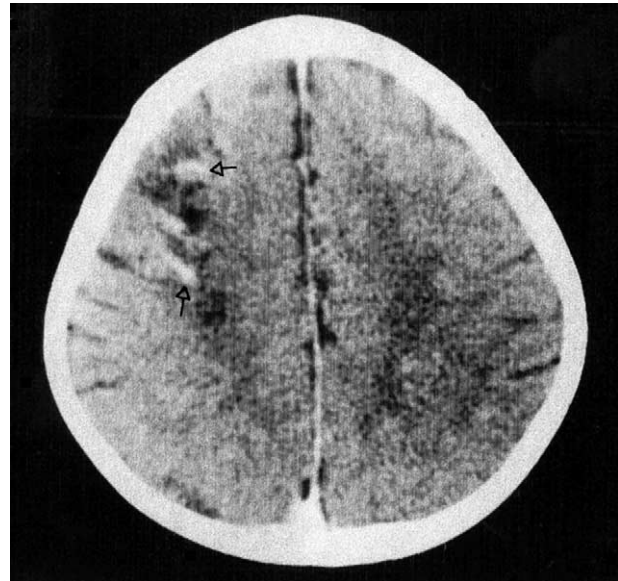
Post contrast CT study showing patchy multifocal enhancing areas at corticomedullary junctions (open arrows).
